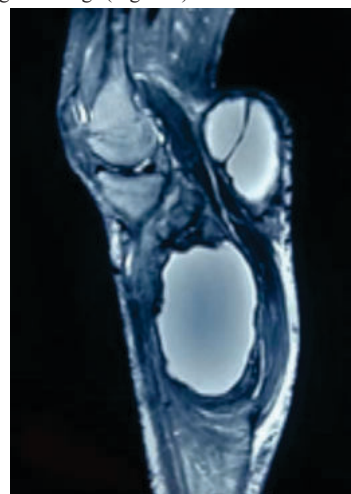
Sagittal section of the MRI
